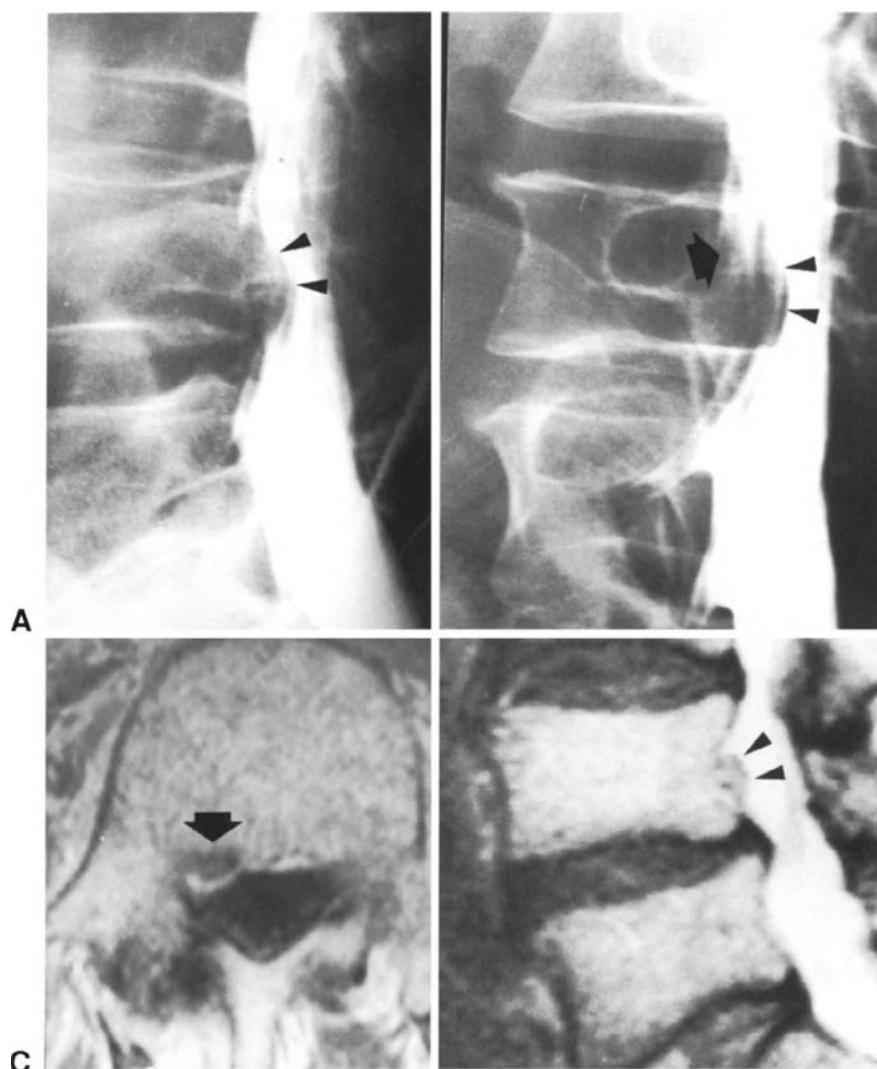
Myelograms and MRI scans of a patient with recurrent herniation at L4-L5 level. The myelograms obtained before primary discectomy show, on the lateral view (A), a large disc fragment migrated behind the L4 vertebral body (arrowheads) and, on the oblique view (B), amputation and trumpet-like dilation of the L4 nerve-root sleeve (arrow) and a filling defect of the thecal sac (arrowheads). MRI performed 4 years after primary discectomy shows, on axial scan (C), a recurrent herniation migrated cranially in the right nerve-root canal and, on sagittal scan (D), a small fragment migrated cranially to the L4-L5 disc (arrowheads).
